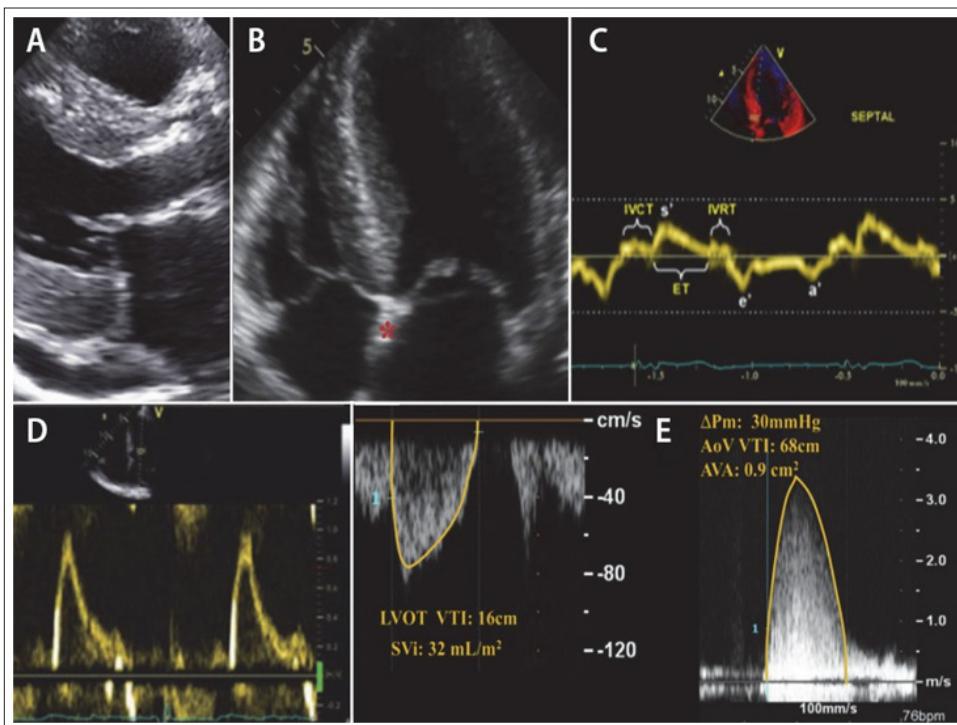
Echocardiographic Findings Suggestive of Cardiac Amyloidosis [2]
